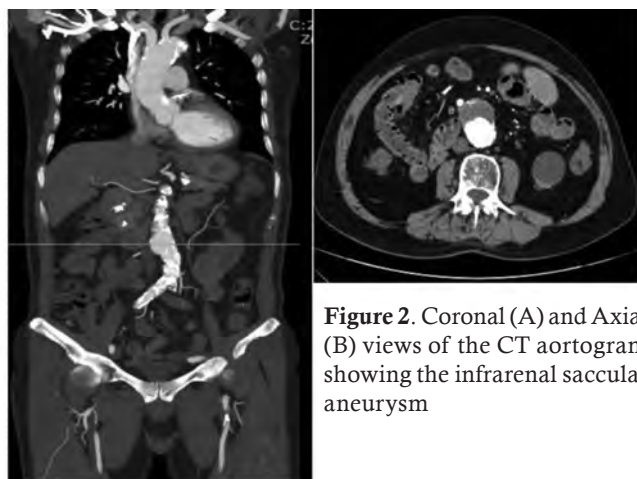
Coronal (A) and Axial (B) views of the CT aortogram showing the infrarenal saccular aneurysm
